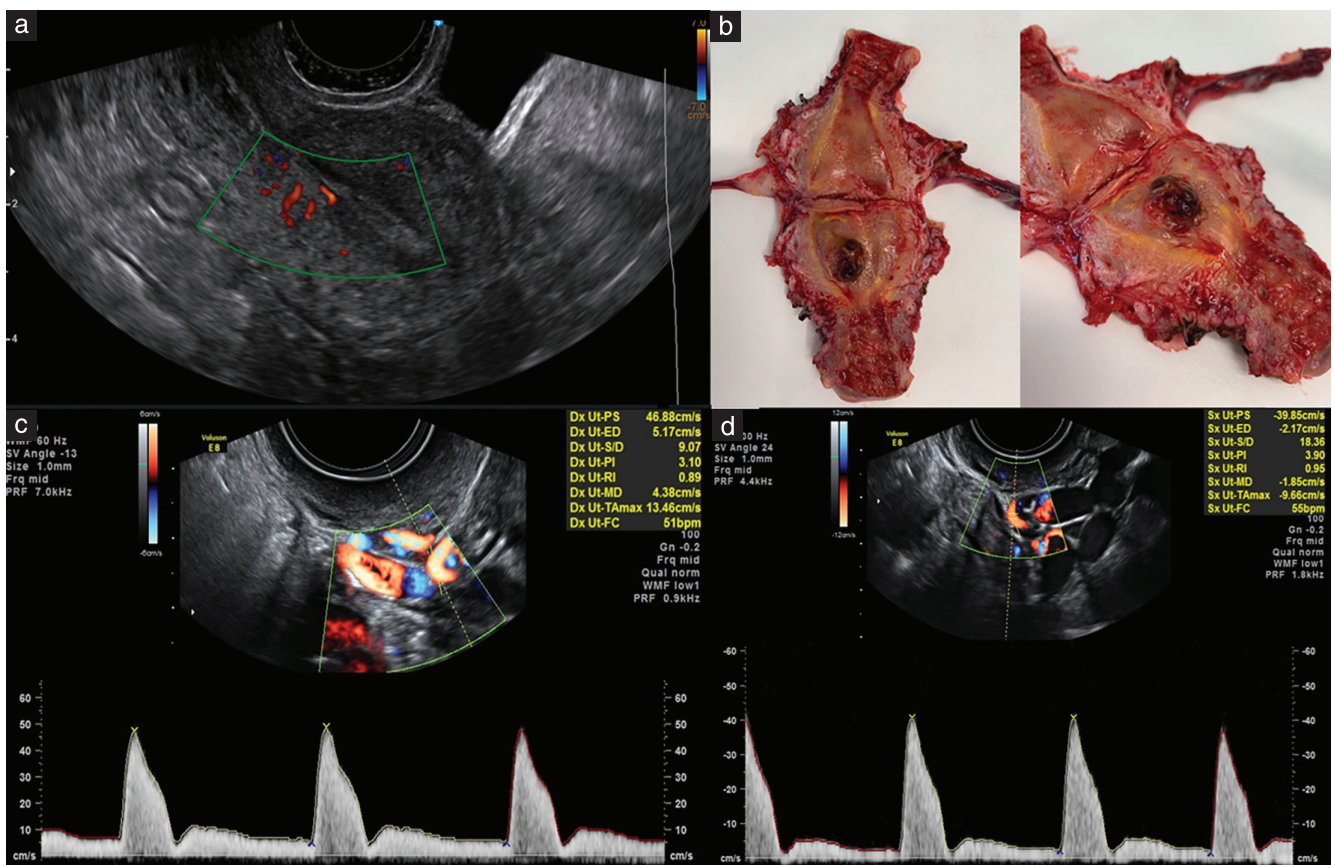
Transvaginal ultrasound imaging of placental site trophoblastic tumor (PSTT) nodule of posterior uterine wall. (a) Longitudinal section of uterus with power Doppler interrogation of region of interest. (b) Macroscopic appearance of PSTT nodule in (a) after hysterectomy, seen as necrotic lesion infiltrating inner half of myometrium on posterolateral wall of uterus. (c,d) Spectral Doppler images and waveforms showing right (c) and left (d) uterine arteries.
